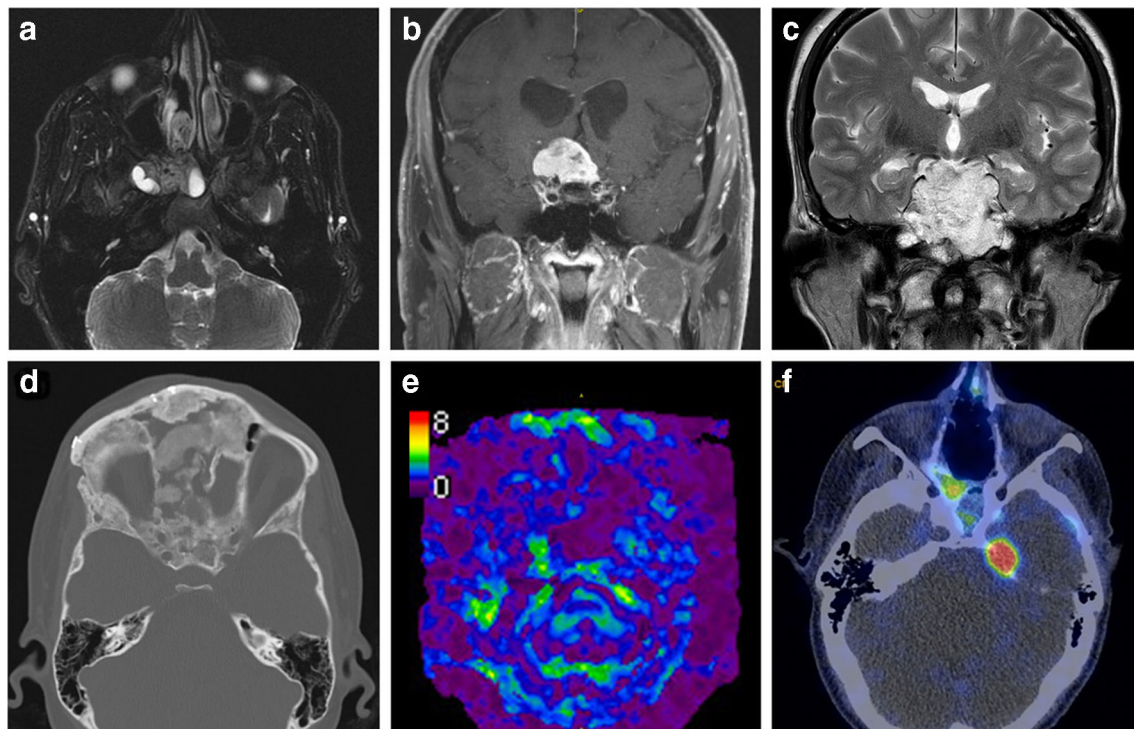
a Juvenile Nasopharyngeal Angiofibroma. Axial T2 MRI with fat suppression shows T2 intermediate signal and internal flow voids. Extension into the pterygopalatine fossa is seen. b Planum sphenoidale meningioma showing avid contrast enhancement and enhancing dural tail on coronal T1-weighted MRI with gadolinium. c Chordoma. Coronal T2-weighted MRI shows a lobulated, heterogeneously hyperintense tumor. d
